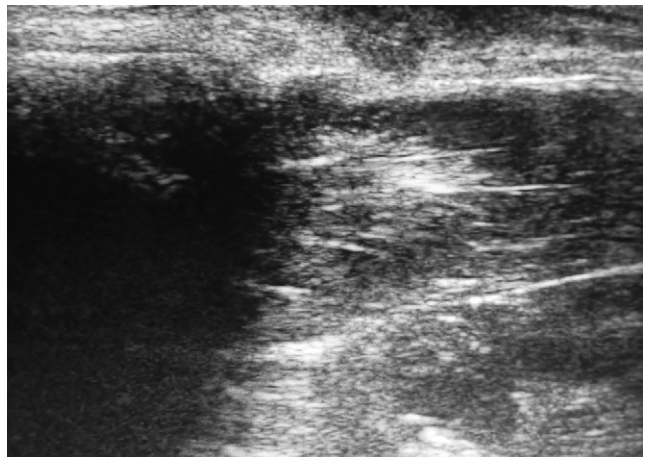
Mucous cyst of the III finger, recurrence after the surgery. Ultrasonography: the circled area shows a cavity of a mucous cyst with a pedicle from the distal interphalangeal joint
